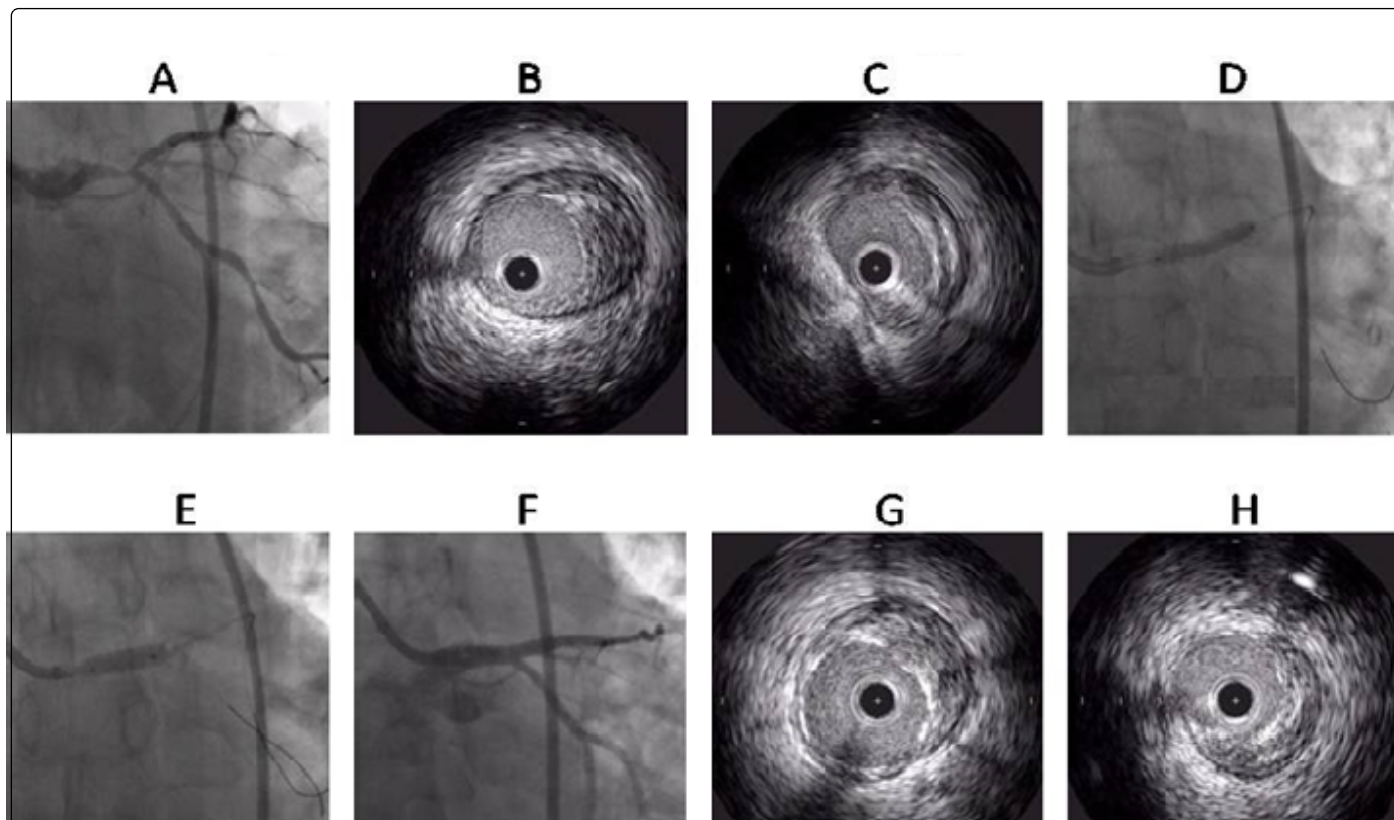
Integrated use of intravascular ultrasound (IVUS) and fractional flow reserve (FFR) in LM bifurcation PCI, A. Coronary angiography (CAG) showed "true" LM bifurcation lesion (Medina 1,1,1), B. IVUS revealing significant left anterior descending artery (LAD) disease, C. IVUS showing very minimal disease at left circumflex artery (LCX) ostium, D. Provisional stenting of LM-LAD. E. Proximal optimization technique (POT) with non compliant short bigger balloon, F. Post stenting FFR of LCX: 0.90, G. IVUS demonstrating minimal stent area (MSA) of 6.5 mm² at LAD ostium, H. IVUS interrogation of LCX showing MSA of 4.2 mm² at ostium.
